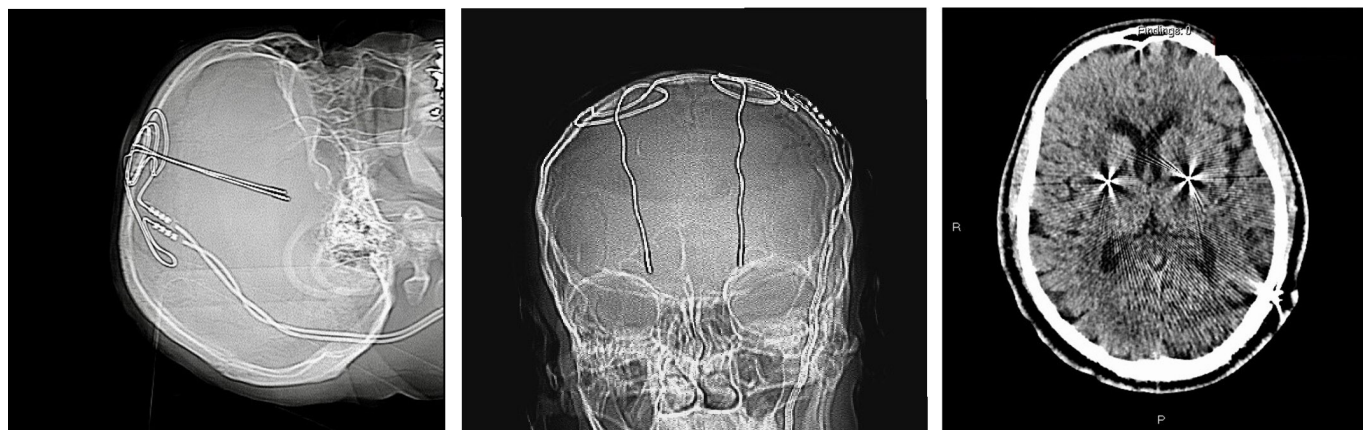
CT images demonstrating the position of the deep brain stimulator (DBS) wires in the brain.
